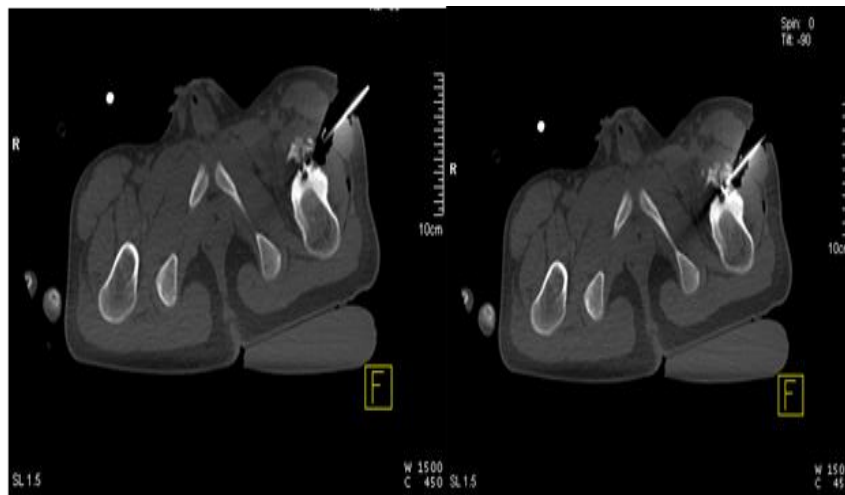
Case 1 Male, 16 years old, recurrence osteoid osteoma of proximal femur after operation, 2018-10-18, intraoperative CT localization image.
